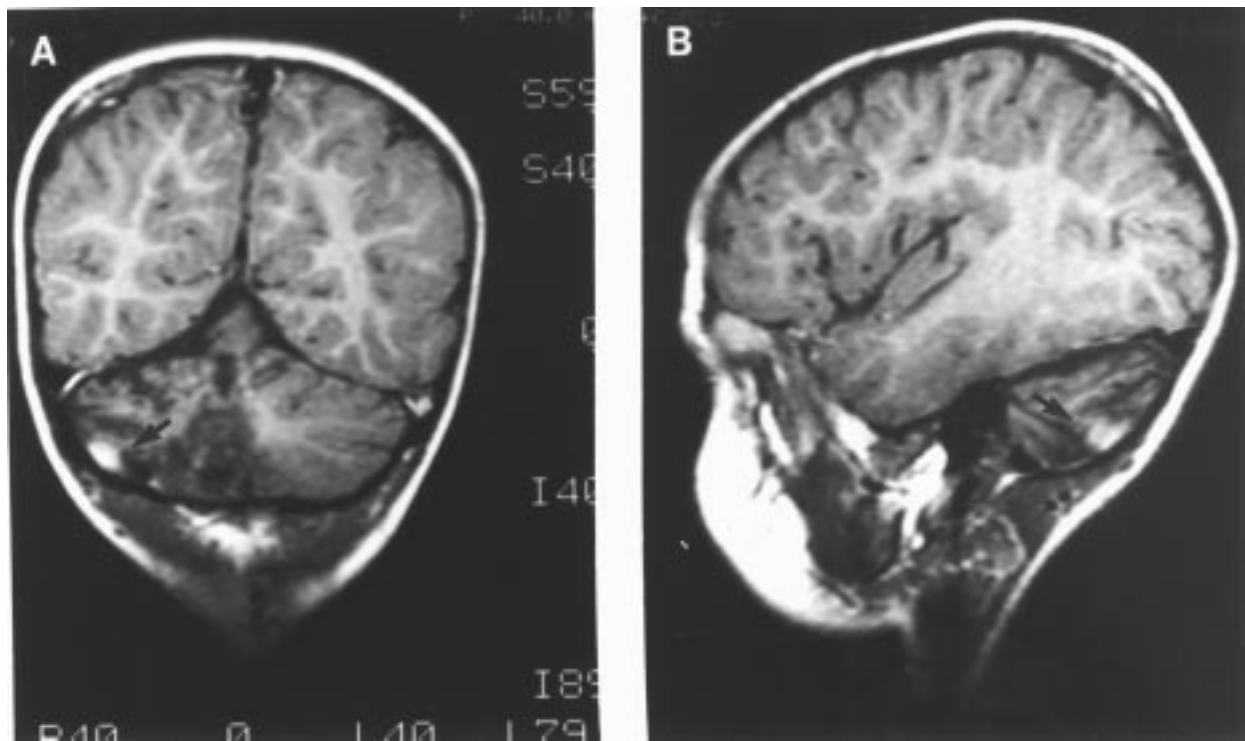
A: T1-weighted coronal postcontrast MR image shows nodular region of contrast enhancement superficial to the right cerebellar hemisphere in the postsurgical region. B: T1-weighted sagittal postcontrast MR image shows similar finding superficial and posterior to the right cerebellar hemisphere. Findings are suspicious for a nodular focus of tumor recurrence or leptomeningeal dissemination.
